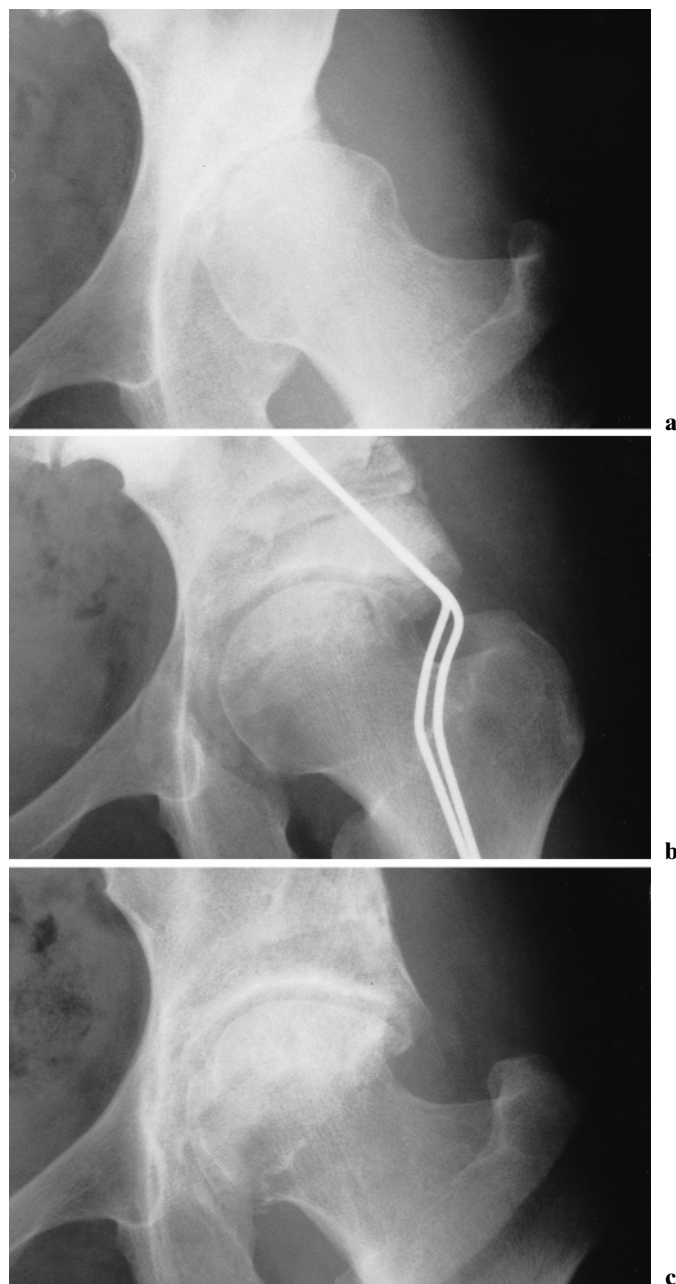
Case 13. a Preoperative radiograph of the left hip in a 38-year-old woman shows findings of stage III coxarthrosis, according to our modification of the classification for coxarthrosis advocated by the Japanese Orthopaedic Association.^{14,21} b One month after rotational acetabular osteotomy, the transferred acetabulum covers the femoral head and is fixed to the pelvis with two wires. c After 13 years, the patient could walk without limitation; the radiograph shows findings of stage II coxarthrosis
